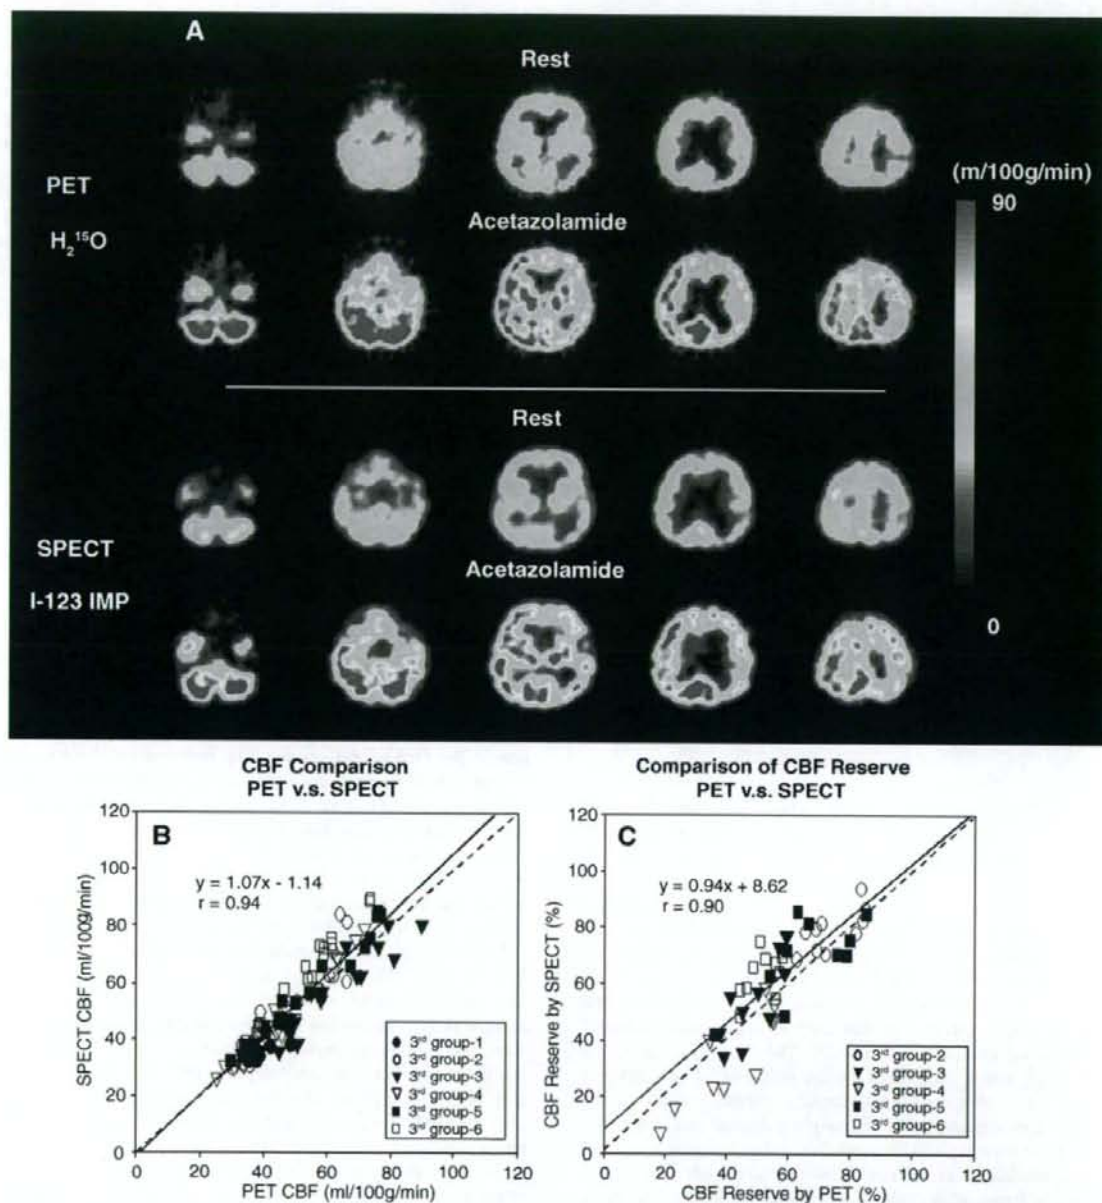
(A) A comparison of calculated CBF images obtained by PET (top two) and SPECT (bottom two) from a typical clinical study with the rest-acetazolamide protocol. CBF images are shown for both first (first and third rows) and second (second and fourth rows) scans, respectively, and reveal that the present method is comparable with that by PET in CBF estimation. CBF images obtained by the present method (bottom two) were also compared with those (top two) by the conventional H<sub>2</sub><sup>15</sup>O ARG PET. All images are displayed with the same color scale in units of ml/100 g/min. (B) Comparison of calculated CBF values obtained from the rest-acetazolamide studies with dual-headed camera and PET ( $n=6$ ). Each value corresponds to a mean value of regions of interest in each area of deep and cortical gray matter (frontal, temporal, occipital gyri) and cerebellum. (C) Comparison of %increase of CBF values calculated with the CBF values of (B). %Increase of CBF was calculated by  $[(\text{CBF}(\text{acetazolamide})/\text{CBF}(\text{rest})) - 1] \times 100$ .
